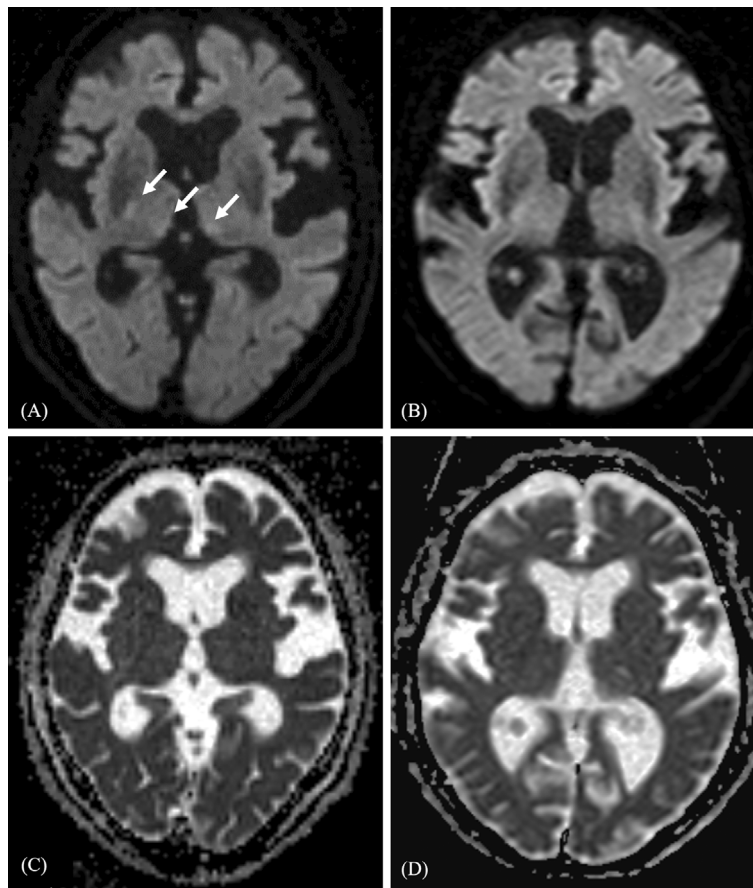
Magnetic resonance imaging (MRI) of cerebral diffusion-weighted imaging (DWI) sequences (A, B) and apparent diffusion coefficient (ADC) maps (C, D). MRI was conducted immediately after the appearance of conjugate deviation of the eyes to the right and left hemiplegia. The hyperintensities of the right posterior limb of the internal capsule and the medial thalamus on DWI (white arrows in A) and hypointensities on ADC map (C) are shown. Changes disappeared entirely on the third day after transfer (B, D).
